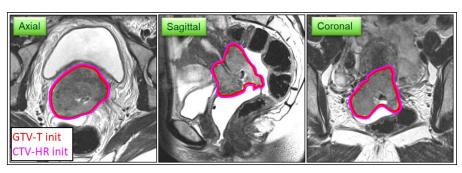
Delineation of CTV T HR init. Pelvic T2w FSE MRI in a patient with an infiltrative cervical cancer, bilateral parametrial spread, invasion of lower uterine segment and posterior vaginal fornix. Stage T2bN0 M0 (FIGO IIB). Representative slices in three main image orientations are shown. Gel (bright signal) was injected into the vagina to improve depiction of the regions of interest. In this case, delineation of CTV T HR init encompasses GTV T init (high-signal intensity lesion) without additional margins. There is no remaining normal appearing cervical tissue present. Therefore, CTV HR init is identical to GTV T init.
